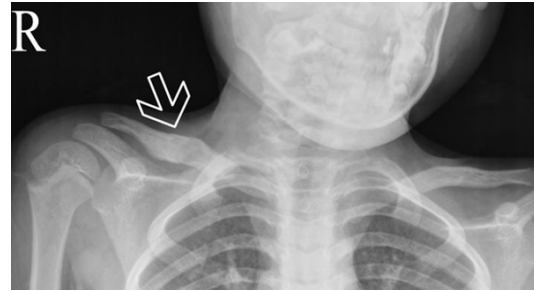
The plain radiograph of the clavicle at 24 months postoperative, showing bony union of the pseudarthrosis (arrow).
